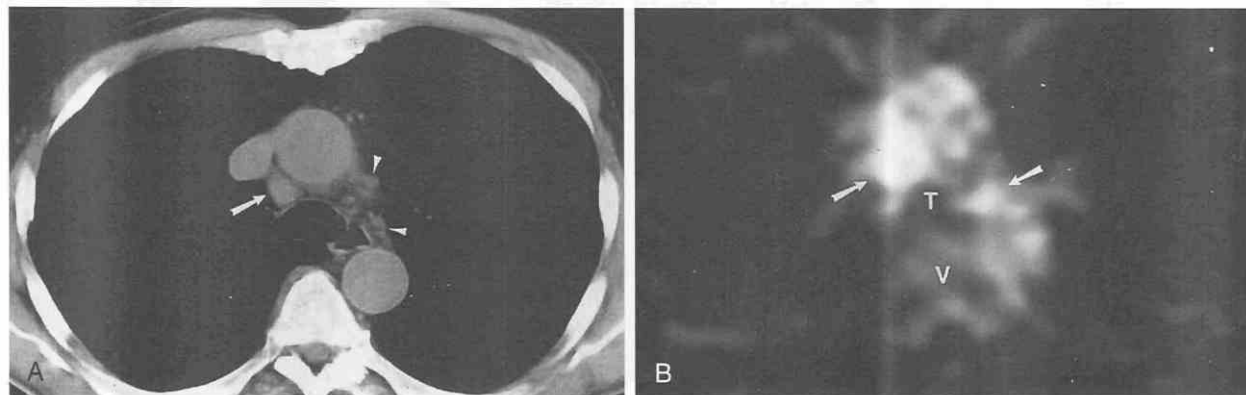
Non-small-cell lung cancer and intrathoracic nodal metastasis. A, CT shows an 11-mm right paratracheal node (arrow) and smaller, normal-sized aortopulmonary window lymph nodes (arrowheads). B, Axial PET image with ^{18}F -fluorodeoxyglucose (FDG-PET) shows markedly increased uptake in mediastinal nodes. Mediastinoscopy confirmed metastatic disease (arrows). T, trachea; V, vertebral body.
